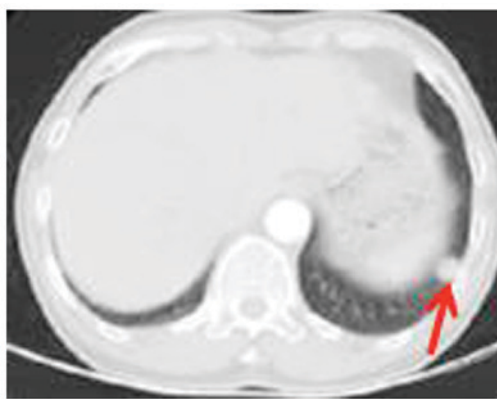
CT scan of the chest demonstrated a 1.5x1.5 cm left lung mass (red arrow). CT, computed tomography.
